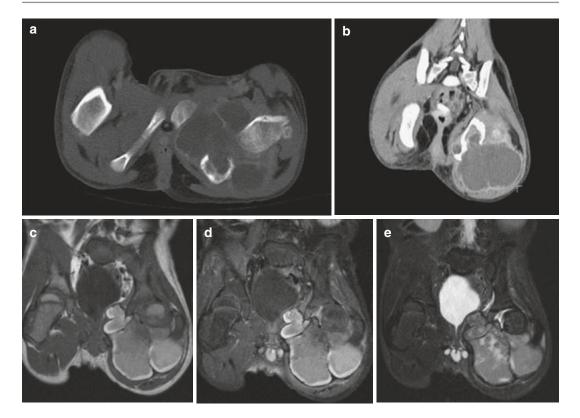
A 5-year-old boy with AFH of the bone. (a, b) Axial and coronal CT. (c) Coronal T1-weighted MR image. (d) Coronal T1-weighted gadolinium-enhanced fatsaturated MR image. (e) Coronal STIR MR-image. Axial and coronal reformat CT scan images demonstrate an expansile lytic lesion with a large cortical break in the left posterior ischium (a). The mass is predominantly fluiddensity with thin, enhancing septations, and an extensive extraosseous component. Coronal T1-weighted MR image demonstrates a lobulated intraosseous left ischial mass
